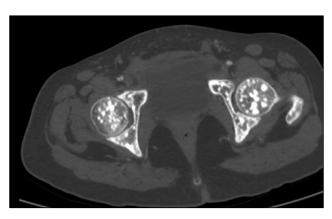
Transverse cross-section computed tomography scan passing through the femoral head. It shows numerous hyperdense lesions that conform with the osteopoikilosis in the femoral head; lesions are well-circumscribed and are measured in millimeters.
